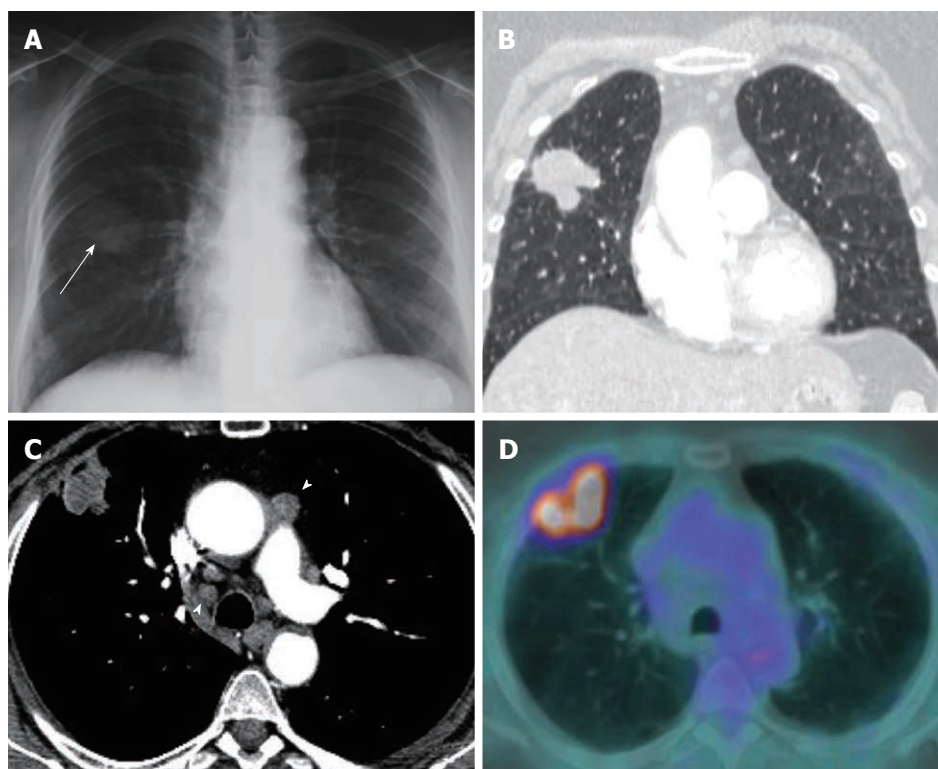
Example of cross sectional imaging nodal staging pitfalls. A: A mass of the right lung (arrow) was identified on chest radiograph. B: A 4 cm spiculated mass suspected of lung cancer in the right upper lobe was confirmed by computed tomography (CT); C, D: Contrast enhanced CT demonstrated enlarged lymph nodes (> 1 cm in short axis; arrowheads) in ipsi- and contra-lateral mediastinal nodal stations (C) (T2aN3), positron emission tomography-computed tomography (PET-CT) (D) showed high metabolic activity of the parenchymal lesion but no nodal [18F]-2-fluoro-2-deoxy-d-glucose uptake (PET-CT staging: T2aN0M0). No metastatic nodes were demonstrated by endoscopic ultrasound-needle aspiration and mediastinoscopy, and surgical staging was in full agreement with PET-CT (pT2N0 adenocarcinoma).
